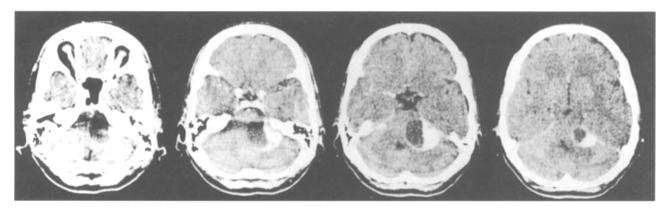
CT-scan from the same patient as in Fig. 4. Partly cystic acoustic neurinoma with preserved hearing pre- and postoperative
